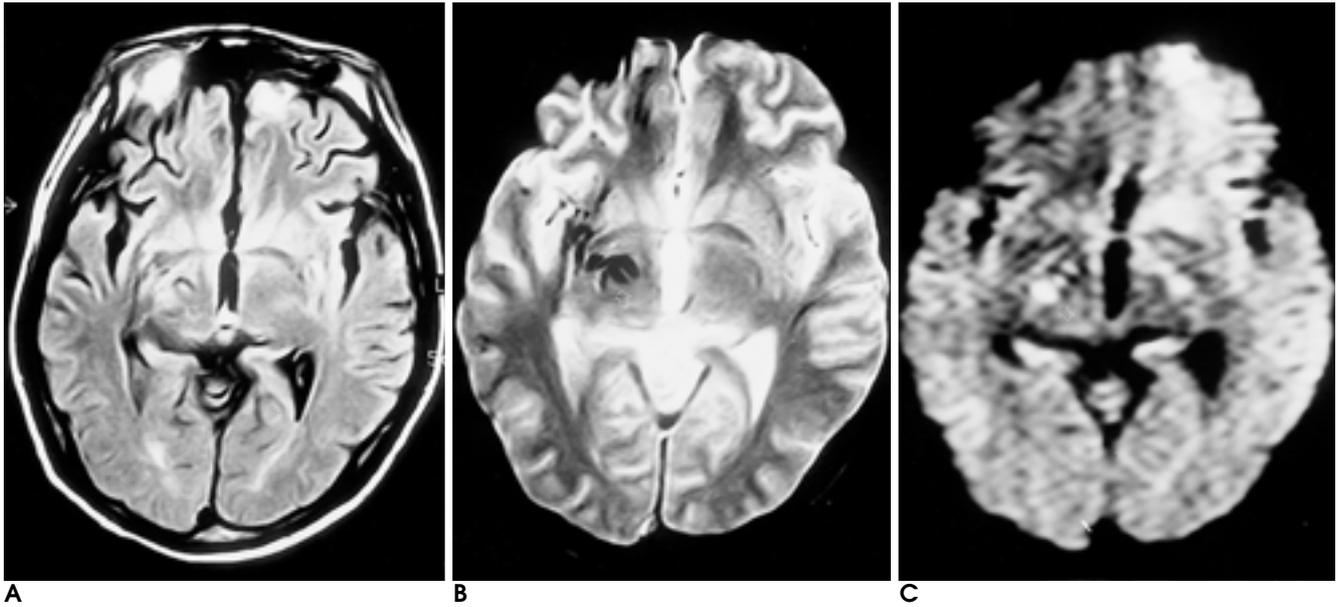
Small petechial hemorrhage in 16-year-old man. FLAIR(A), T2 FFE(B) and diffusion weighted(C) images show right thalamic hemorrhage. But Right. basal ganglia low signal intensities due to hemorrhage only detected on T2 FFE images.
